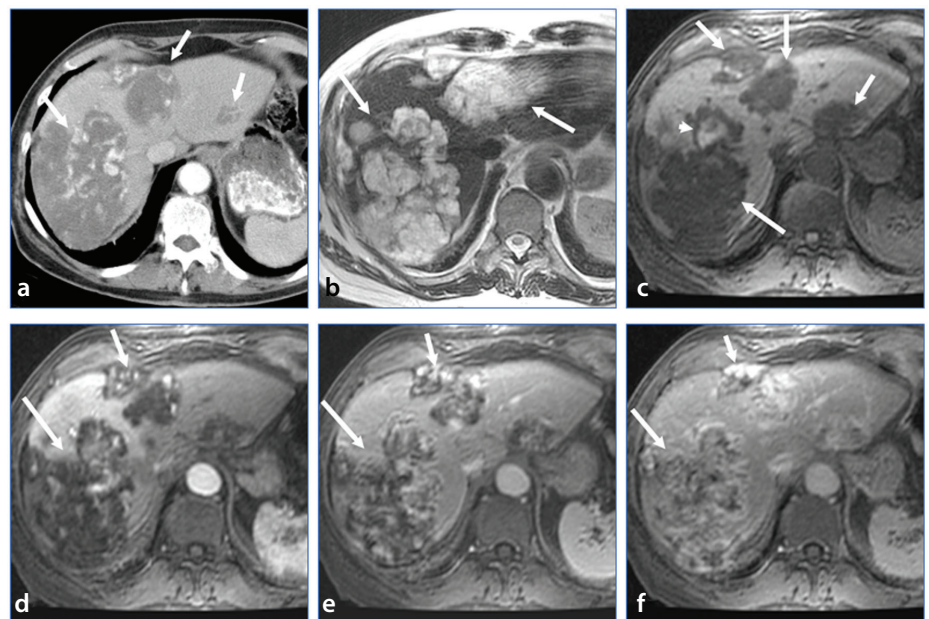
Angiosarcoma. Axial contrast-enhanced computed tomography (CT) (a), axial T2-weighted magnetic resonance imaging (MRI) (b), axial T1-weighted MRI (c), and dynamic post-gadolinium T1-weighted MRI with fat suppression (d-f) show multifocal liver angiosarcomas (long arrows). The masses demonstrate low attenuation relative to the liver on contrast-enhanced CT, high T2 signal intensity, low T1 signal intensity, and progressive enhancement following contrast administration. Early arterial enhancement is irregular and more central than in hemangiomas. High signal intensity within the lesion on T1-weighted imaging is due to hemorrhage. The T2 signal intensity is more heterogeneous than seen in hemangiomas.
